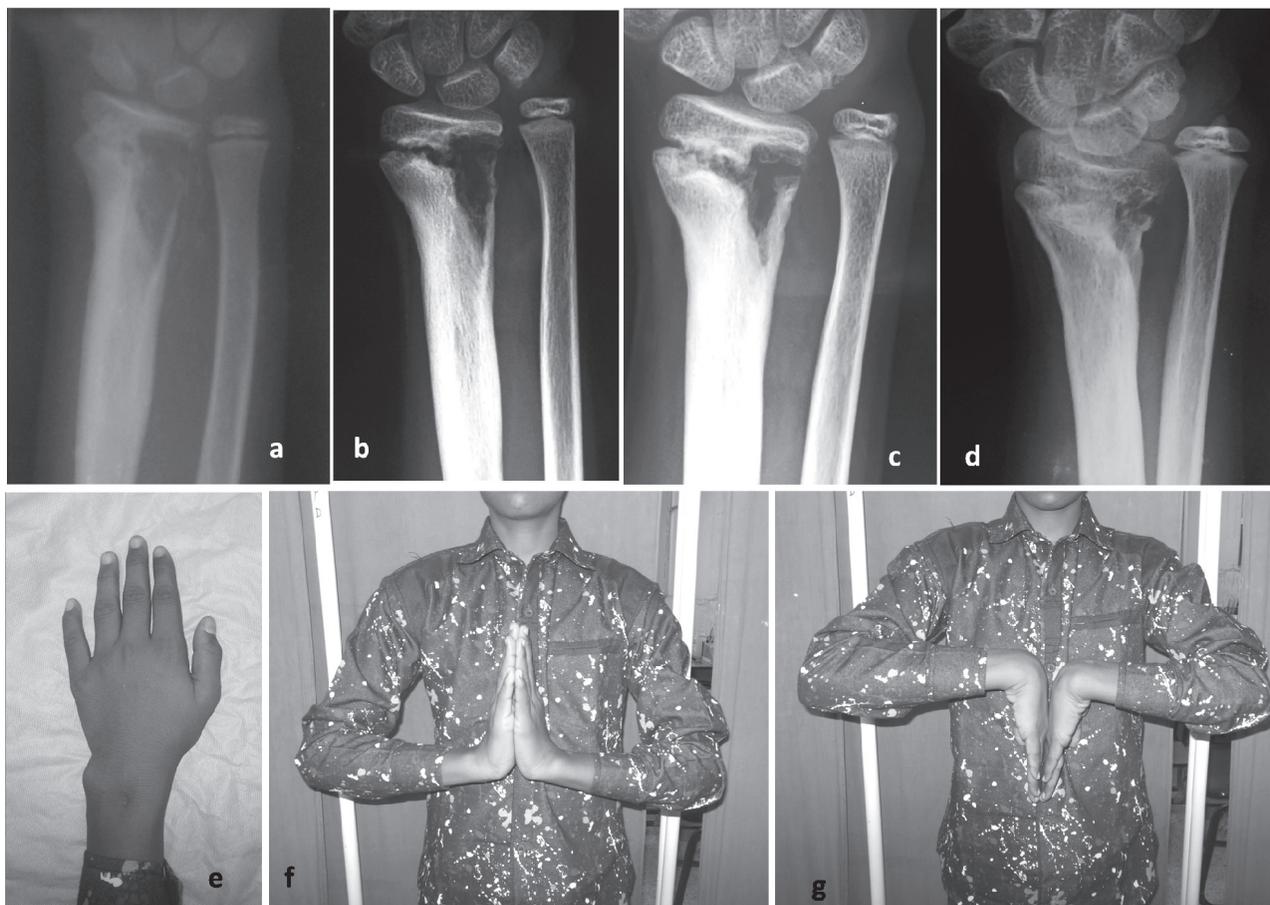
Diffuse lesion (a) Plain radiographs of wrist showing transphyseal diffuse lesion in radius (b) After completion of antitubercular treatment. Sclerosis of the margins can be appreciated indicating healing of the lesion (c) One year post chemotherapy (d) Last follow up 2 years. Premature physeal closure. Some residual lucencies still persist. Except for ulnar prominence (e), the wrist function was preserved well (f,g).
